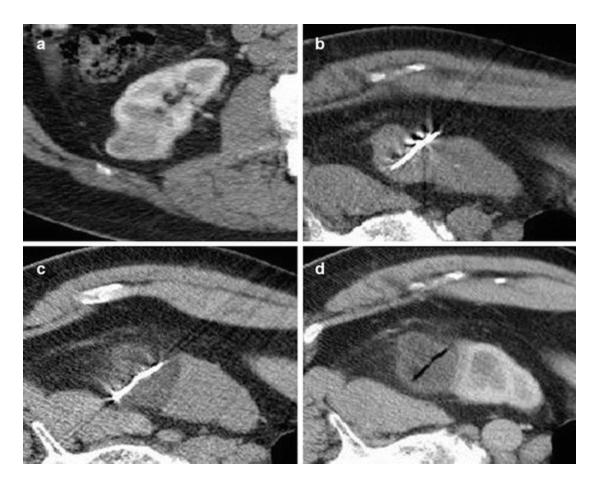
Technique for Percutaneous Renal Cryoablation. (a) 3.1 cm renal mass pre-procedure imaging. (b) Placement of two cryoprobes under US and CT guidance. (c) Imaging at the end of the double freeze-thaw cycle. (d) Post-contrast imaging after removal of cryoprobes [44]
